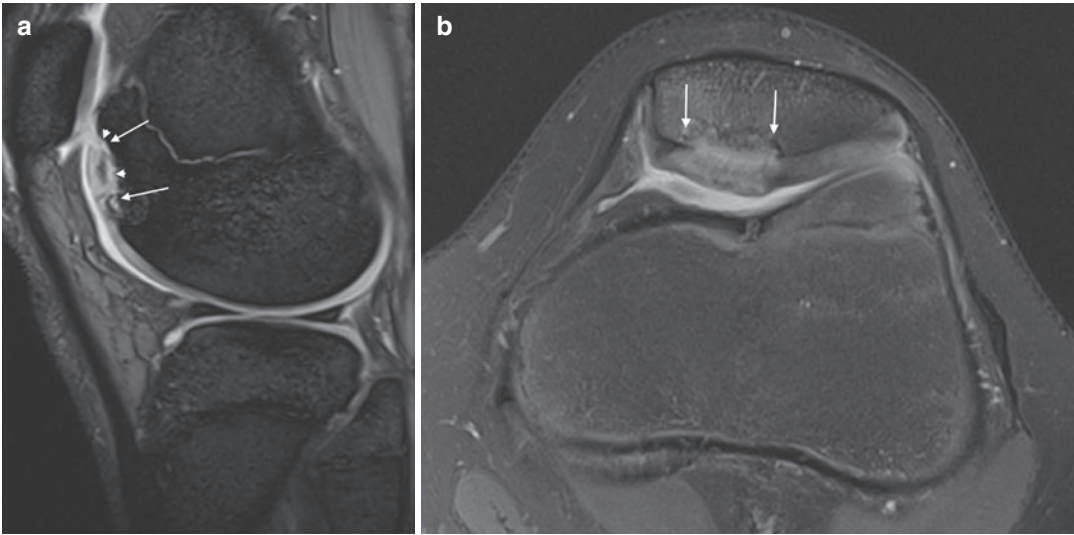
Bipartite patella. Axial proton-density fat saturation MR image showing bipartite patella with oedema in the ossicle (arrow). The overlying cartilage is disrupted (arrowhead)
